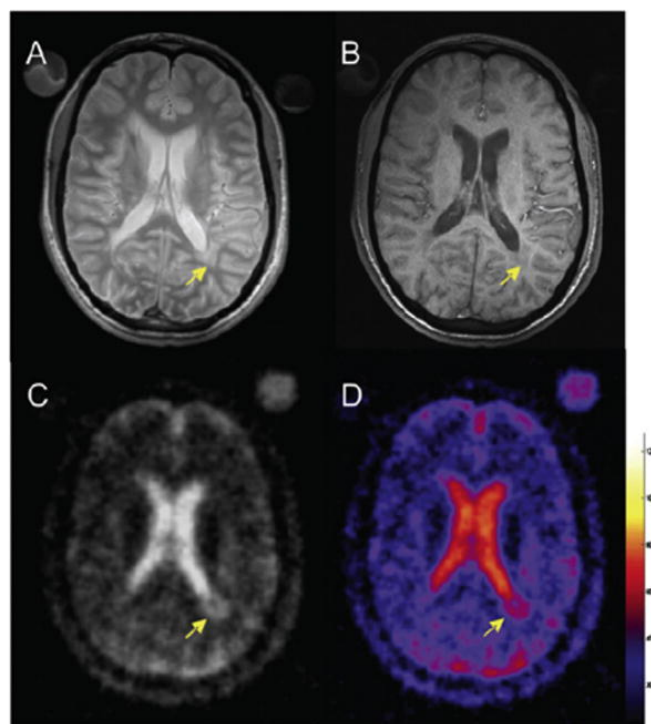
Multiple sclerosis imaging example: A) Proton density MRI, B) T1 weighted MRI, C) sodium MRI, and D) corresponding TSC map
